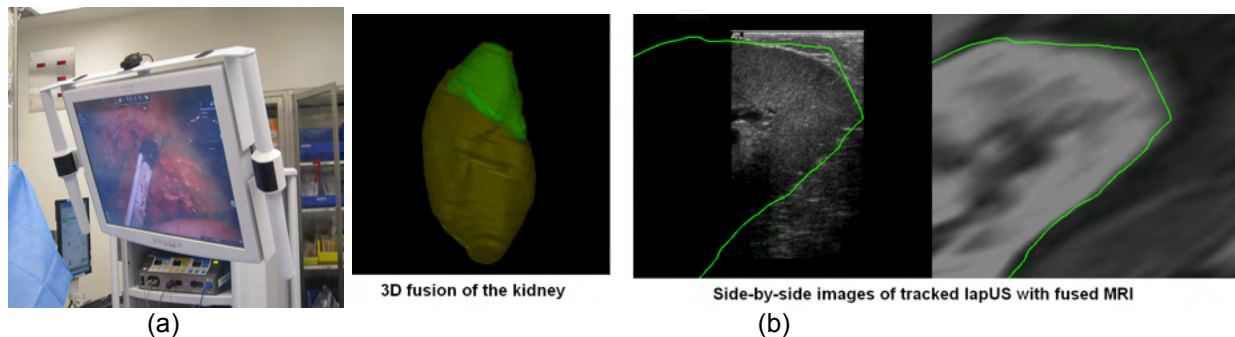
(a) Acquisition of ultrasound images with a laparoscopic probe. (b) Registration results with aligned segmented 3D models and side-by-side images of MRI and lapUS.
